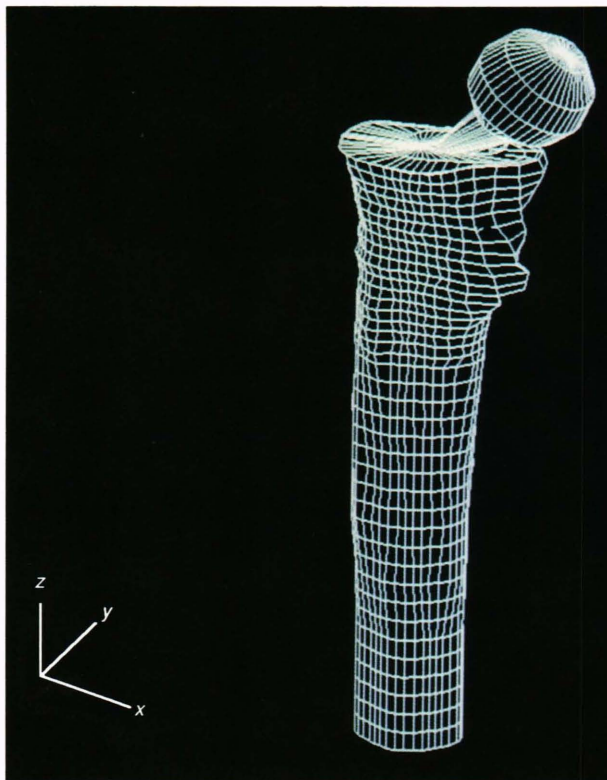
Total hip arthroplasty, fine-mesh model, as generated from computed tomography scan data (5207 nodes, 5040 elements).
